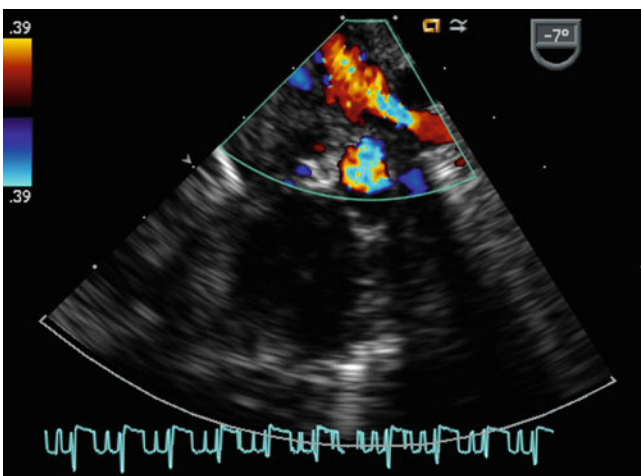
Transesophageal color Doppler image of the left upper pulmonary vein as it courses towards the left atrium. Aliasing is seen by color flow interrogation that should prompt further investigation, including spectral Doppler interrogation
